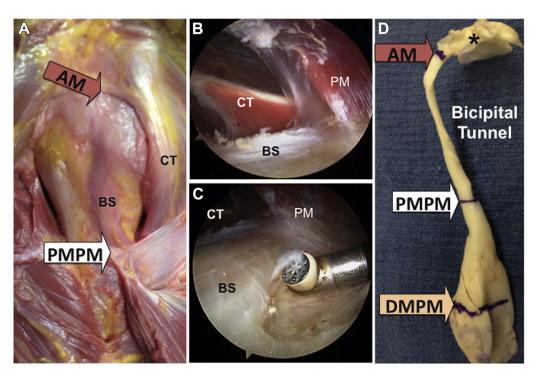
(A) Gross dissection of a right shoulder shows that the bicipital sheath (BS) that envelops the long head of the biceps tendon (LHBT) and runs in continuum with it from the articular margin (AM) through the subpectoralis region distally to the distal margin of the pectoralis major tendon (DMPM). (B) The arthroscopic anatomy is clearly defined in a right shoulder viewed from an anterolateral portal within the subdeltoid space. (C) The bicipital sheath was present in all patients who underwent surgery and can be quite robust. (D) The bicipital tunnel was injected with methacrylate bone cement, allowed to harden, and then dissected to show that the bicipital tunnel is a completely closed space in which space-occupying lesions such as scars, loose bodies, osteophytes, or bony stenosis may become pathologic. (Asterisk defines intra-articular space.) (CT, conjoint tendon; PMPM, proximal margin pectoralis major tendon; PM, pectoralis major.)
